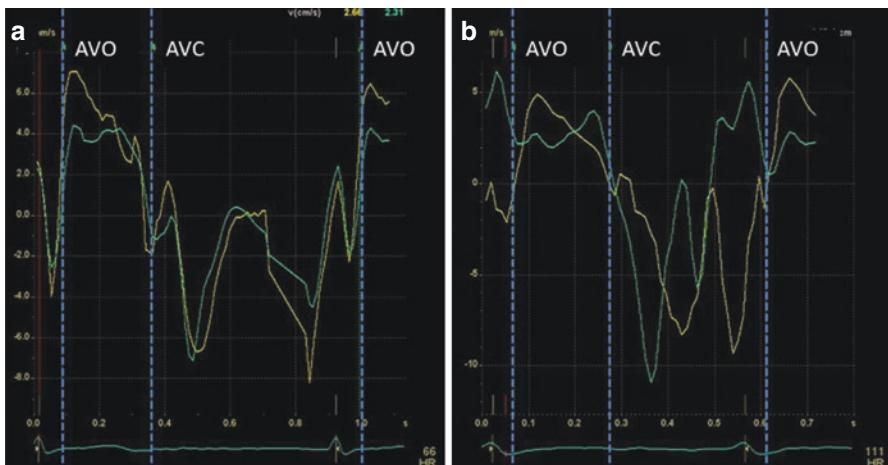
Tissue Doppler velocity tracings with representation of basal septal and basal lateral left ventricular wall segments from a healthy individual (panel a) and a patient with severe systolic heart failure and QRS prolongation (panel b). AVO aortic valve opening, AVC aortic valve closure
